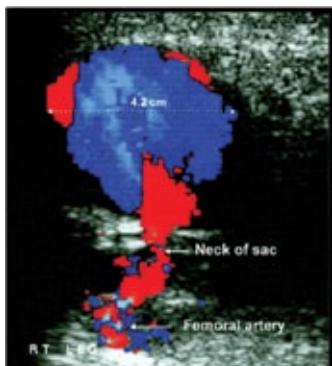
Duplex Doppler of femoral false aneurysm
